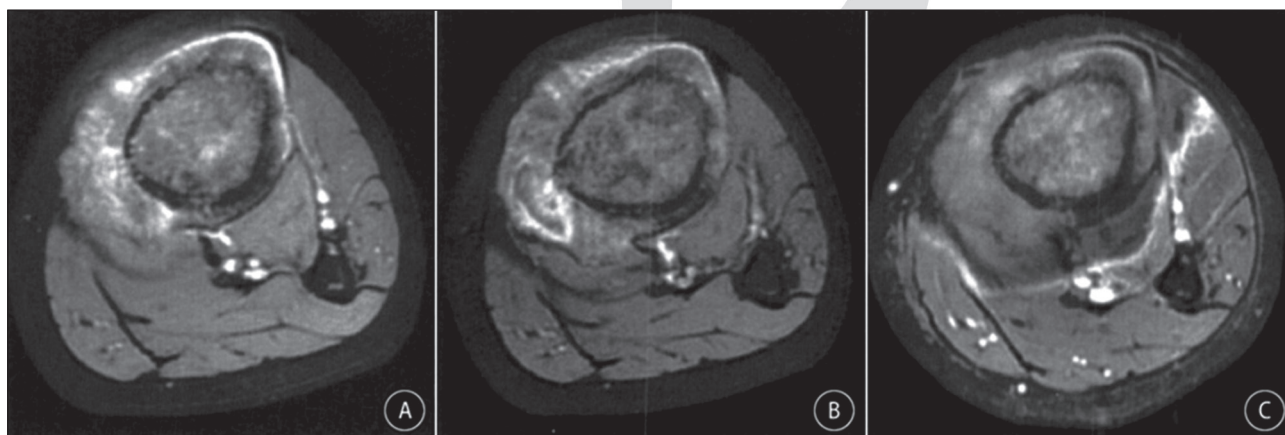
MRI before and after osteosarcoma treatment. A: axial-enhanced image before treatment; B: axial-enhanced image after the 2nd course; C: axial-enhanced image after the 4th course.
